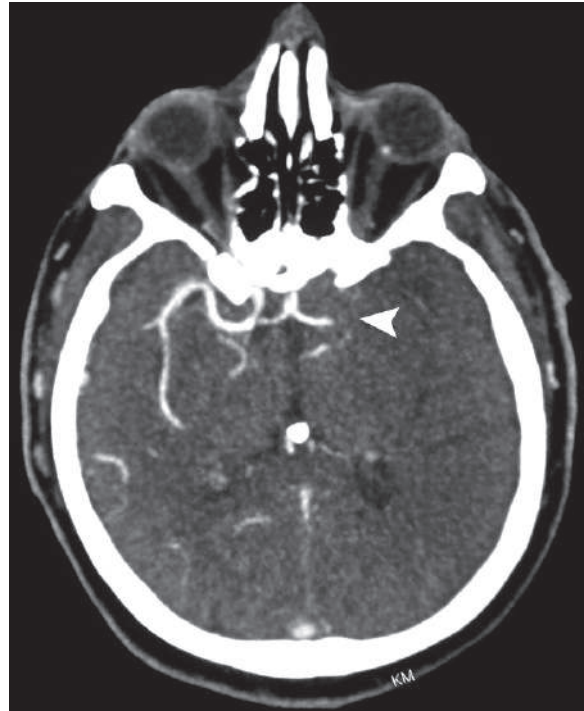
Axial brain CTA image of a patient with left brain infarction shows blockage of the left middle cerebral artery (M1) segment (*arrowhead*)
